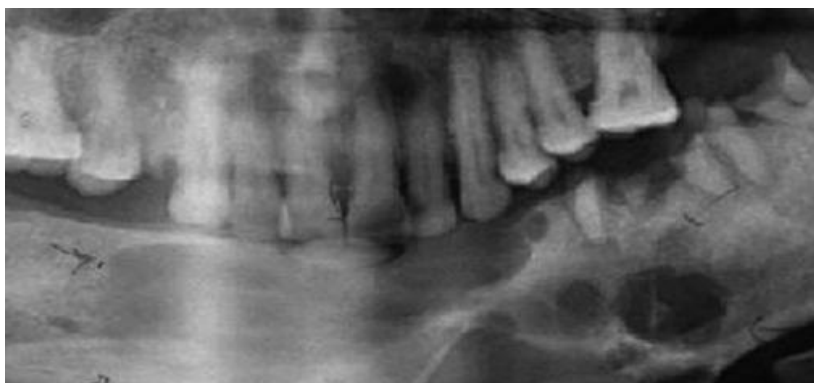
cropped panoramic radiograph showing soap-bubble type. (More et al, 2012)
